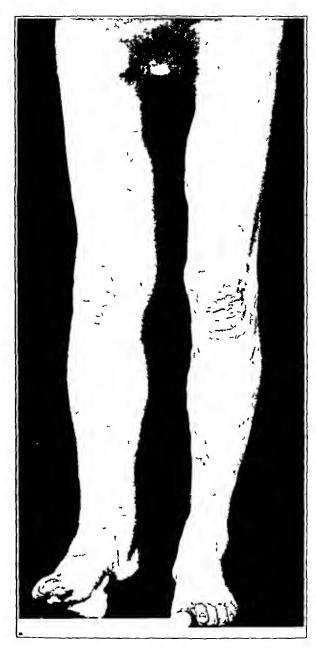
(case 4)—Retouched print of soft tissue roentgenograms or both legs of a patient with a history of varicose veins and ulcer and recurrent attacks of elephantiasic fever in the left lower extremity. There are marked hypodermal trabeculations in the affected limb (From California & West Med 31 233 [Oct] 1929)
